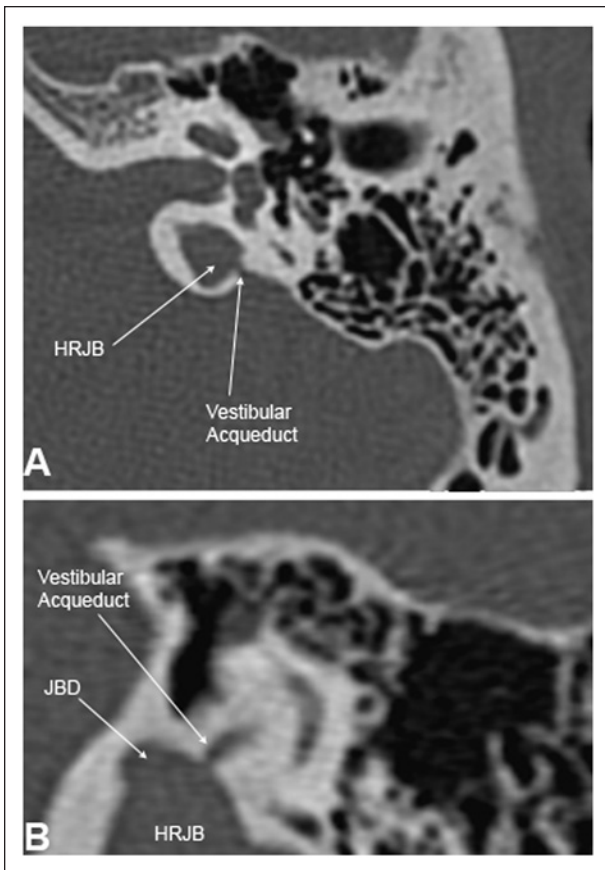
Patient 1: Left temporal computed tomography scan showing a high-riding jugular bulb (HRJB) with a diverticulum (JBD) and dehiscence of the vestibular aqueduct (A, axial view; B, coronal view).
